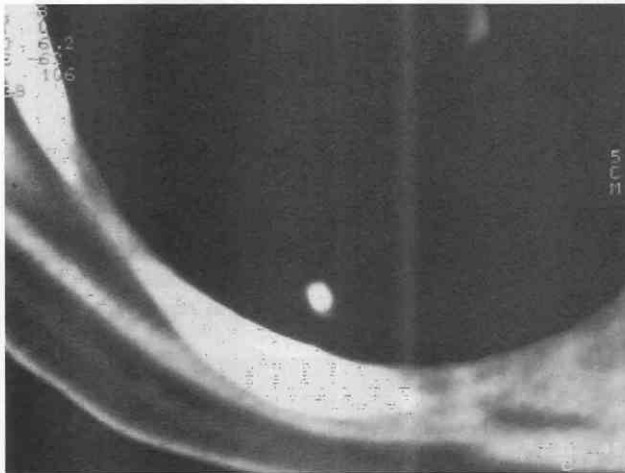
Benign calcified granuloma. Nodule is as dense as the ribs on soft tissue window settings and measures greater than 160 Hounsfield units on a calibrated, noncontrast CT scan.
